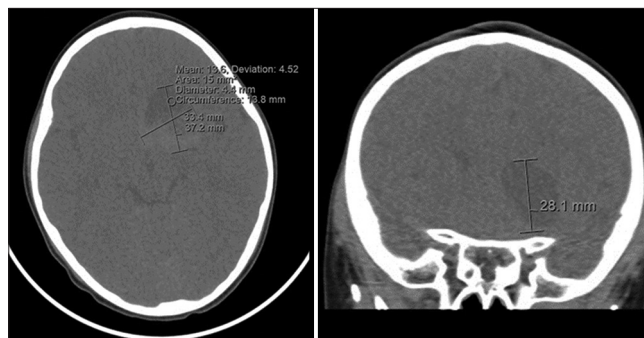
Initial computed tomographic reveals left inferior frontal mass measuring 3.7 × 3.3 × 2.8 cm.
